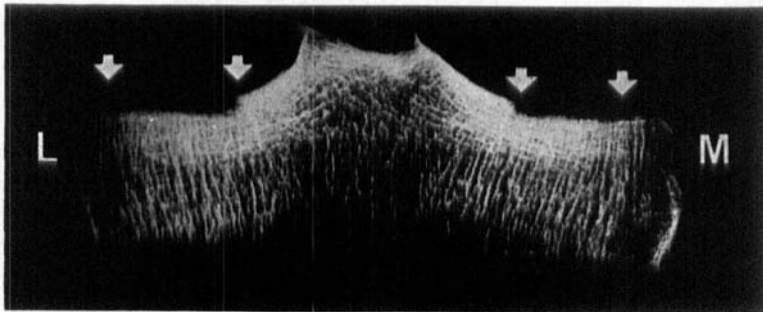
X-ray of 5 mm thick slice of lateral (L) and medial (M) condyles of normal tibial plateau. Cartilage and subchondral bone plate ground away between arrows.
